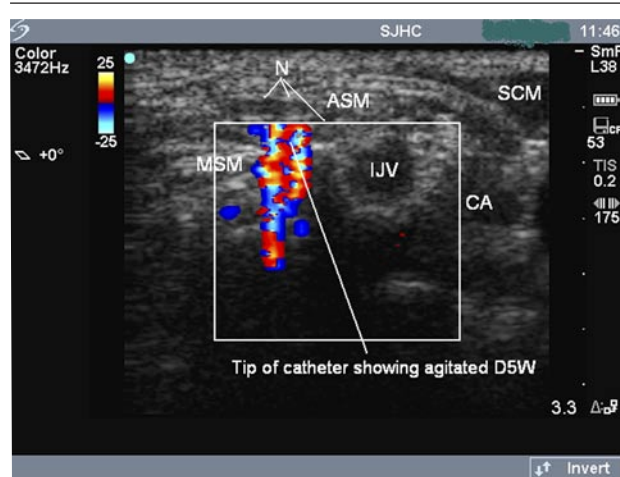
Ultrasound examination of the interscalene area with colour Doppler flow assessment
